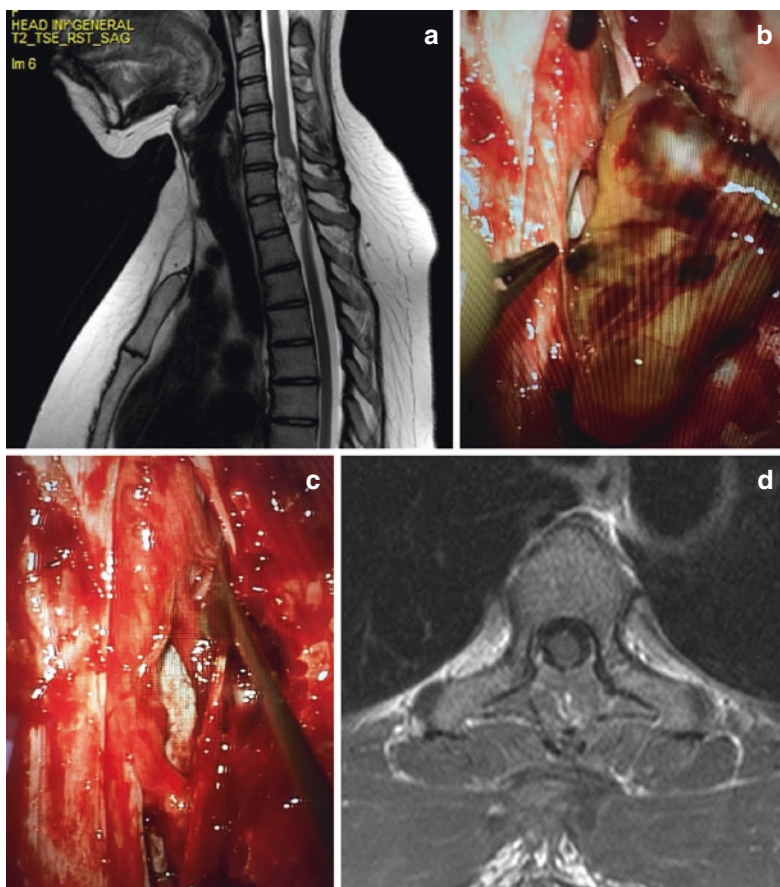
(a) Sagittal T2-weighted MRI image of a 23-year-old patient harboring an intradural schwannoma at the C7–T1 level with intratumoral bleeding. The patient presented high grade paraparesis. (b) Intraoperative image of the patient showing the removal of the lesion via C7–T1 laminotomy. (c) Surgical site after tumor resection. (d) Postoperative axial T1-weighted post-contrast MRI image showing the complete removal of the schwannoma
